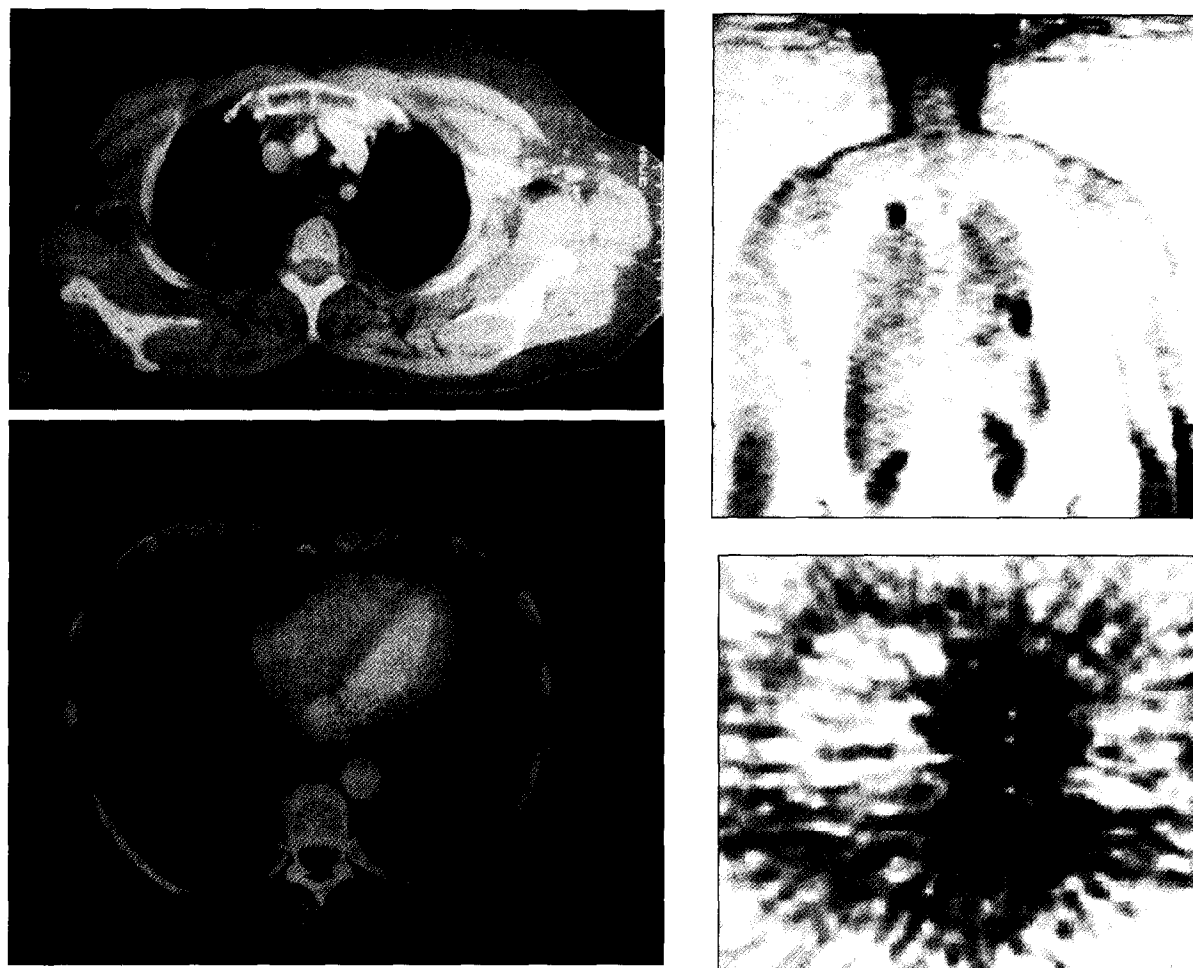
Example of clinical staging in the presence of multiple pulmonary lesions (patient affected by Li-Fraumeni syndrome). (Left) spiral CT showed a lesion in right upper lobe and two lesions in the left lower lobe. (Right) PET confirmed the metabolic activity of the three lesions, without regional or distant metastases. Pathological examination after complete resection was indicative of three independent primary tumours. CT = computed tomography; PET = positron emission tomography.
